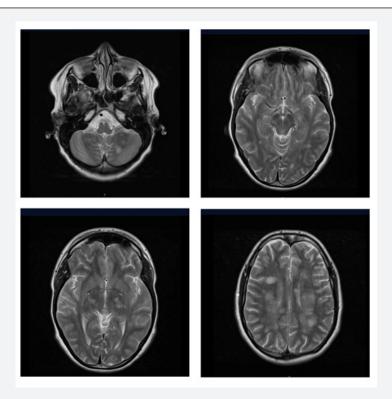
Initial MRI showing hyperintense lesions in cerebellum, brainstem, basal ganglia and subcortical white matter.
